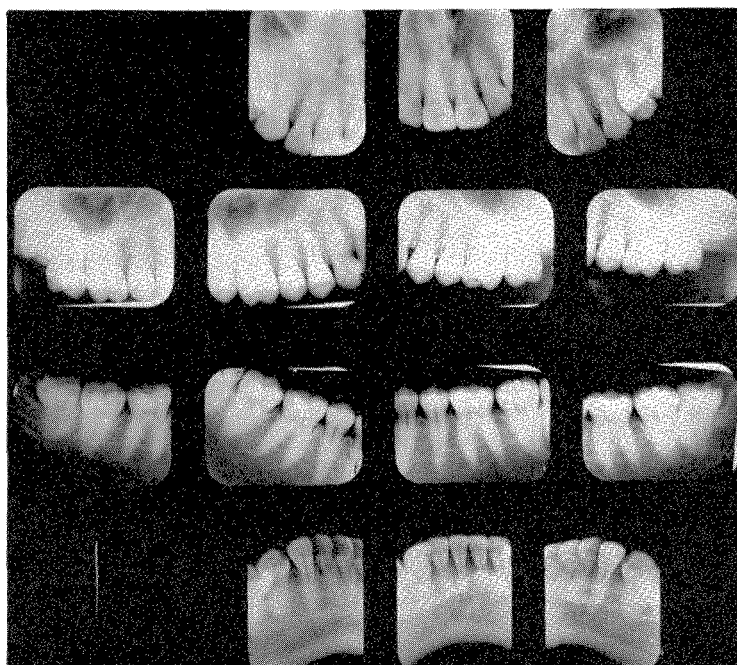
Roentgenograms taken in 1933 at the age of 20.
